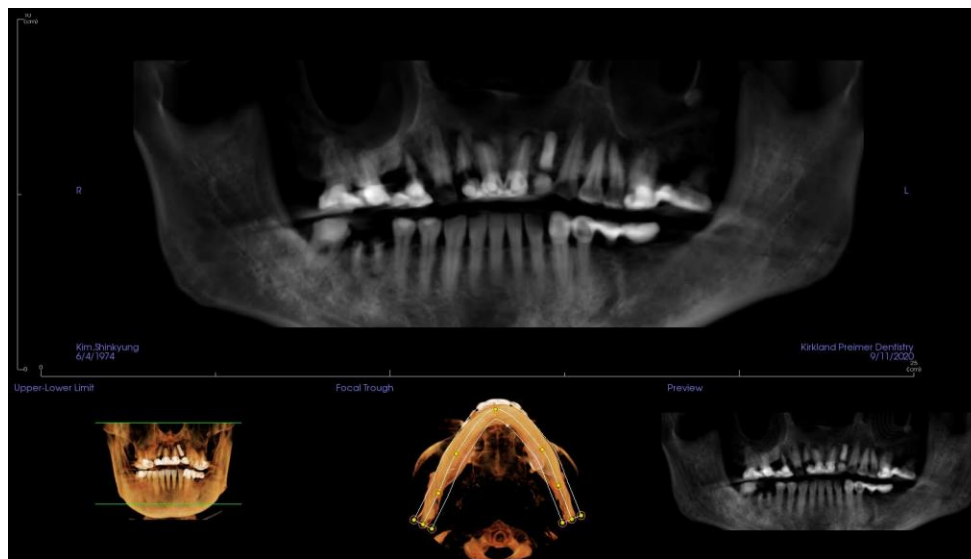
Preoperative CBCT panoramic image, showing chronic periodontal infection, bone loss, and an implant in site 10 with a radiolucency related to tooth 7.
